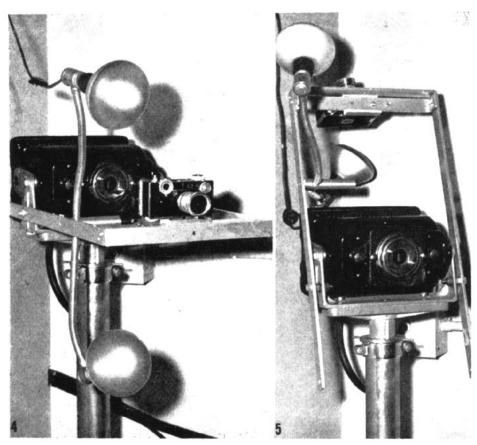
mm. camera and lights mounted on a aluminum frame built around the x-ray head. Camera is on the path of the central ray and at a pre-focused distance from the patient.
